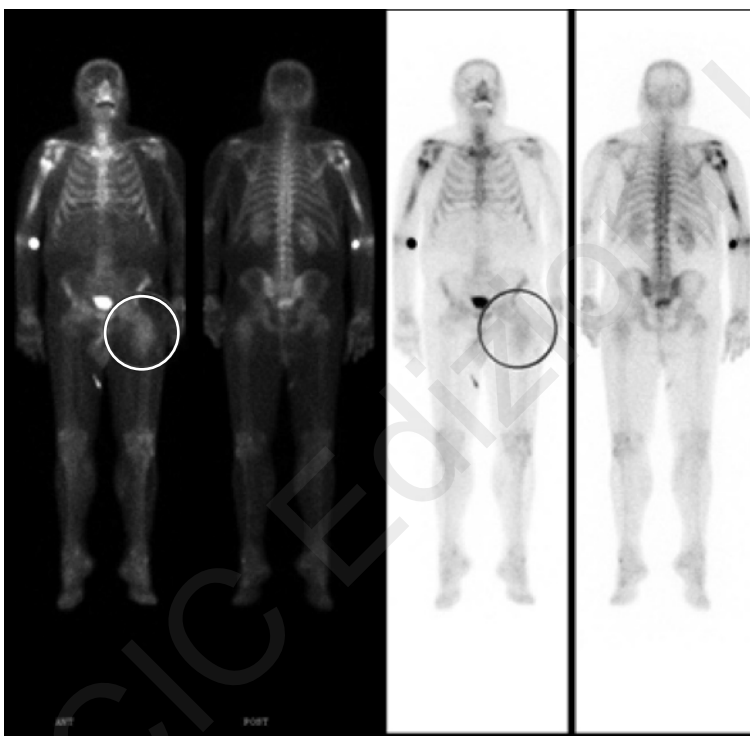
Bone scintigraphy: uptake of left hip.
